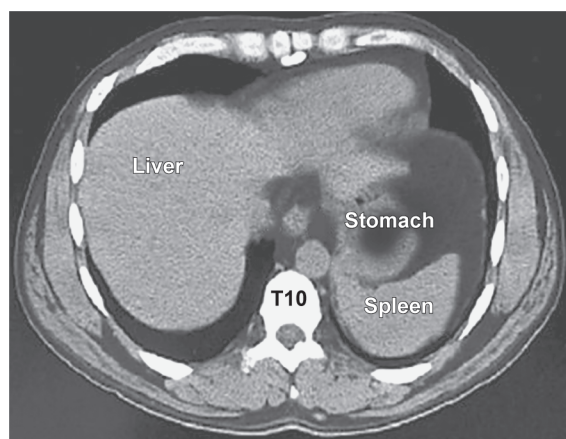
CT scan at level of T10 vertebra
